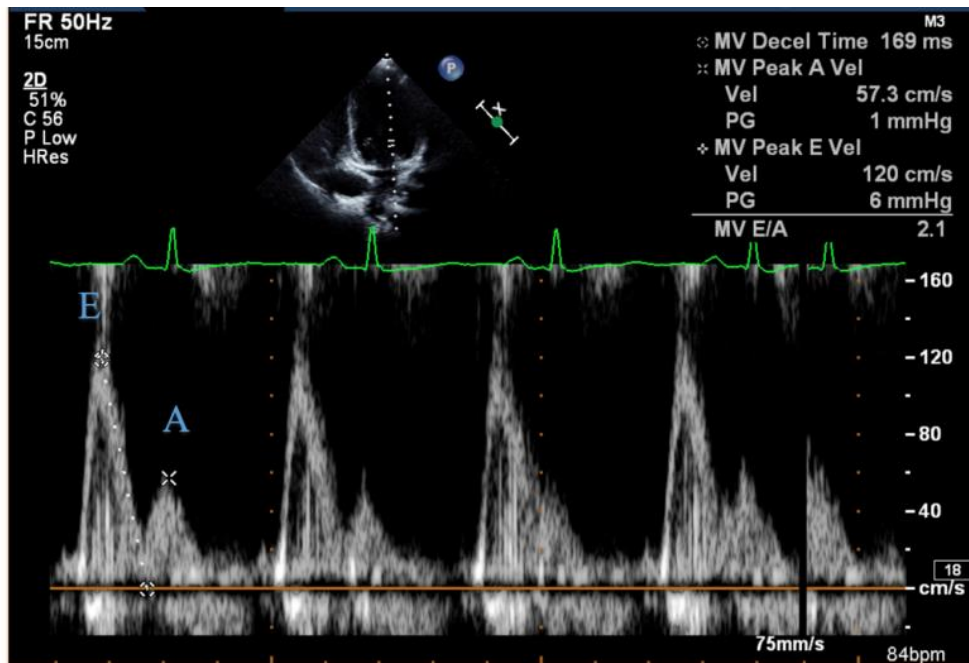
The image shows the transmitral flow curve on Doppler echocardiography. E peak: Rapid early filling peak; A peak, Late filling peak
